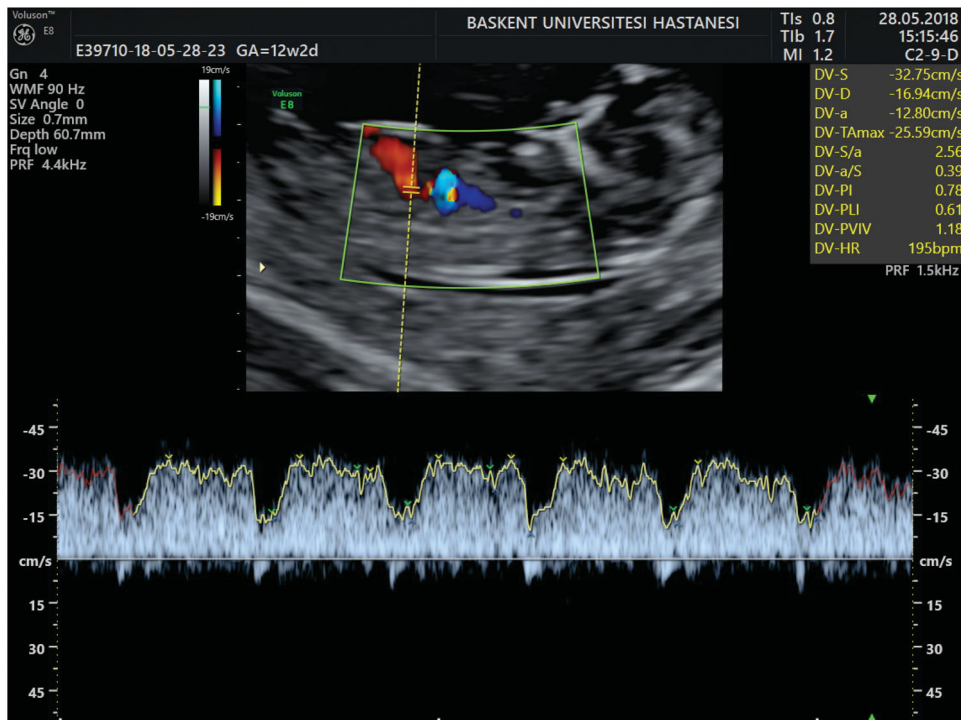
Ductus venosus Doppler measurements.
